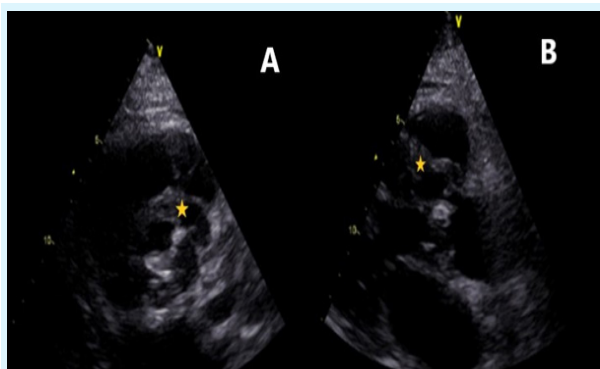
(A) 2D echocardiography parasternal short axis view showing an additional cavity in the aortic annulus anterior to the left main coronary artery non communicated with adjacent structure. (B) parasternal long axis view showing the pseudoaneurysm (asterix).
